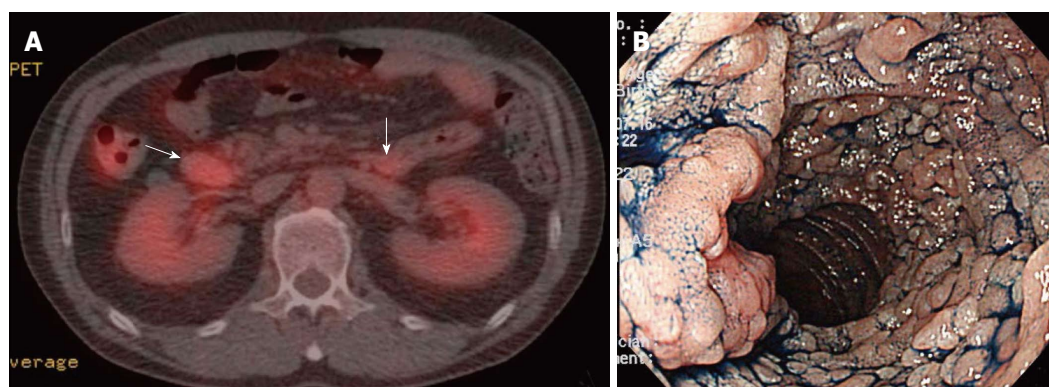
A 52-year-old man with follicular lymphoma of the gastrointestinal tract. A: ^{18}F -fluorodeoxyglucose positron emission tomography combined with computed tomography in transaxial images showed focal hypermetabolic activities (maximum standardized uptake value, 6.6 and 5.5, respectively) in the lesions of the descending portion of the duodenum and the duodenojejunal flexure (arrows), respectively; B: The esophago-gastro-duodenoscopic view with indigo carmine dye-spray of the descending portion of the duodenum. Numerous whitish granules densely clustered together.
